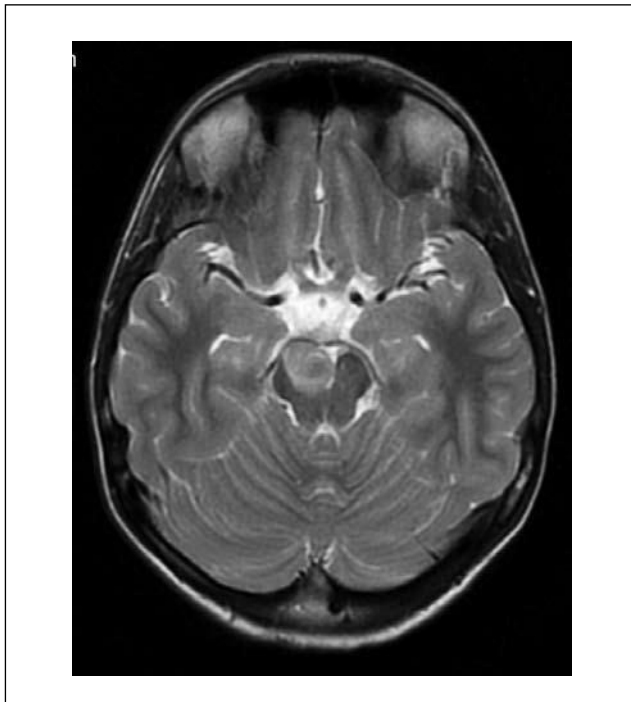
A 12-year-old boy with headaches, without neurological signs and symptoms. MRI, FSE/T2-weighted image, axial plane. Pathological mass in the right cerebral peduncle without oedema of the surrounding tissue, with only trace of contrast enhancement (not shown). Lesion's morphology suggests a benign, slowly growing tumour.
